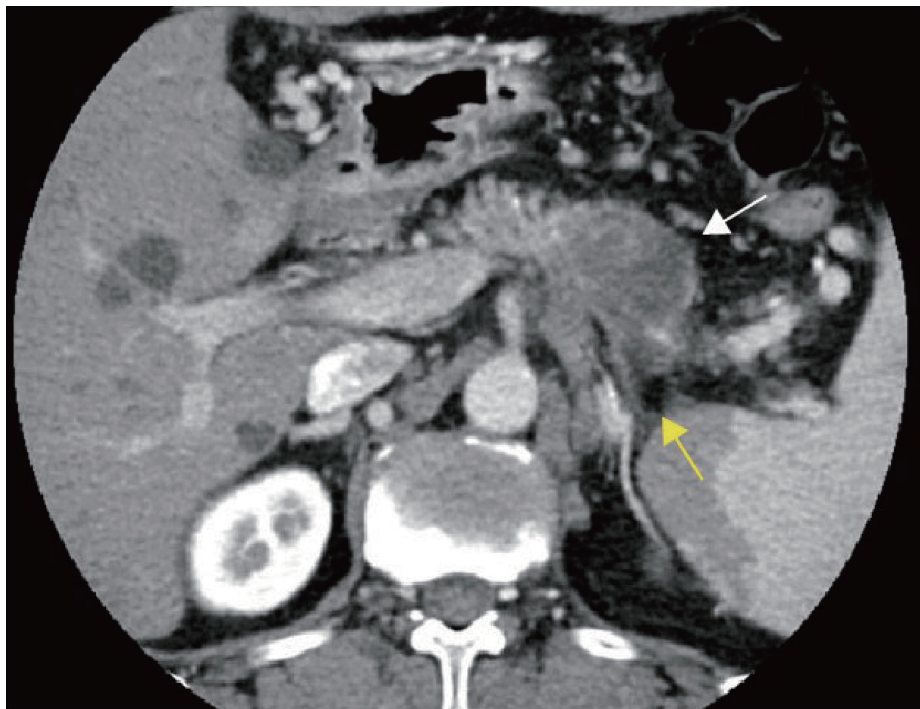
Pancreatic cancer with surrounding obstructive inflammation. Axial arterial late-phase computed tomography (CT) image shows a hypodense mass in the pancreatic body and tail (white arrow), with patchy peripancreatic inflammatory infiltration (yellow arrow).
